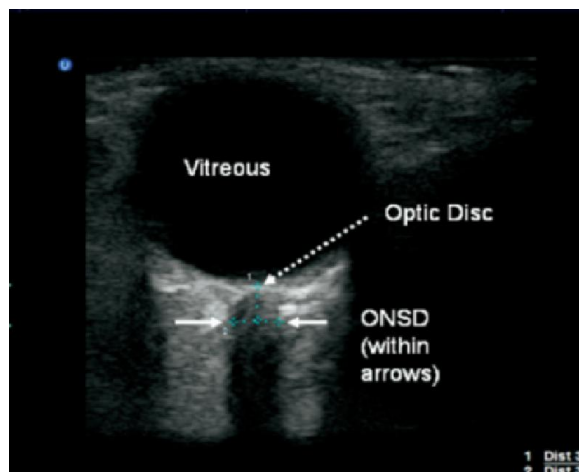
The technique of ocular ultrasound and the image with the cursors set at 3 mm behind the globe to measure the optic nerve sheath diameter¹²
